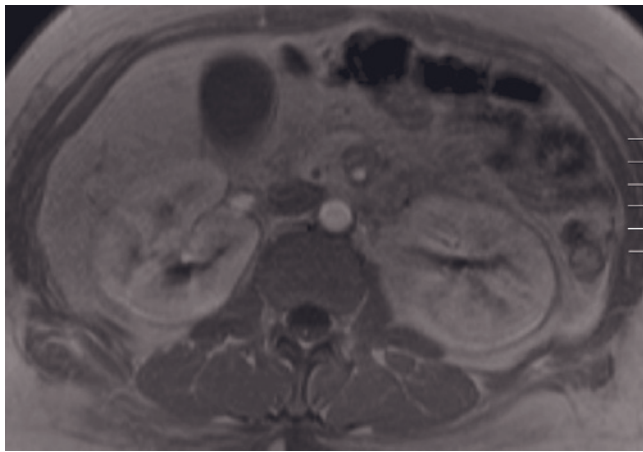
Tubular blockage secondary to Bence Jones proteinuria. T1-weighted precontrast fat-suppressed SE (a), immediate postgadolinium SGE (b), and late-phase fat-suppressed gadolinium-enhanced SE (c) images. This patient with multiple myeloma has high-signal-intensity lesions in the bone marrow and liver and absent CMD on precontrast images (a). On immediate postgadolinium image (b), CMD is present, but cortical enhancement is not intense. On interstitial-phase image (c), diffuse high signal intensity is present in the renal medulla, suggesting the presence of tubular leakage of gadolinium. Tubular blockage secondary to rhabdomyolysis. T1-weighted precontrast (d) and precontrast fat-suppressed (e) SGE images. The kidneys are enlarged, with diminished CMD on the precontrast image. Extensive high signal is present in the muscles of the upper thighs (e), which on the noncontrast image reflects diffuse hemorrhagic changes. Coronal T1-weighted gradient-echo (f) and T1-weighted fat-suppressed
